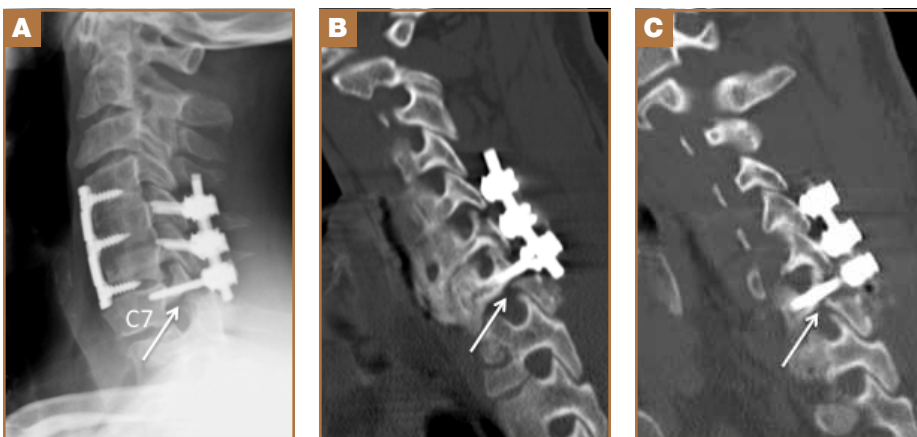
Images after patient had a mechanical fall down a flight of stairs soon after the posterior instrumented fusion. (A) Lateral radiograph suggests C7 pars fracture (arrow). Sagittal CT images from the (B) right and (C) left show bilateral pars fractures at the C7 level (arrows).
